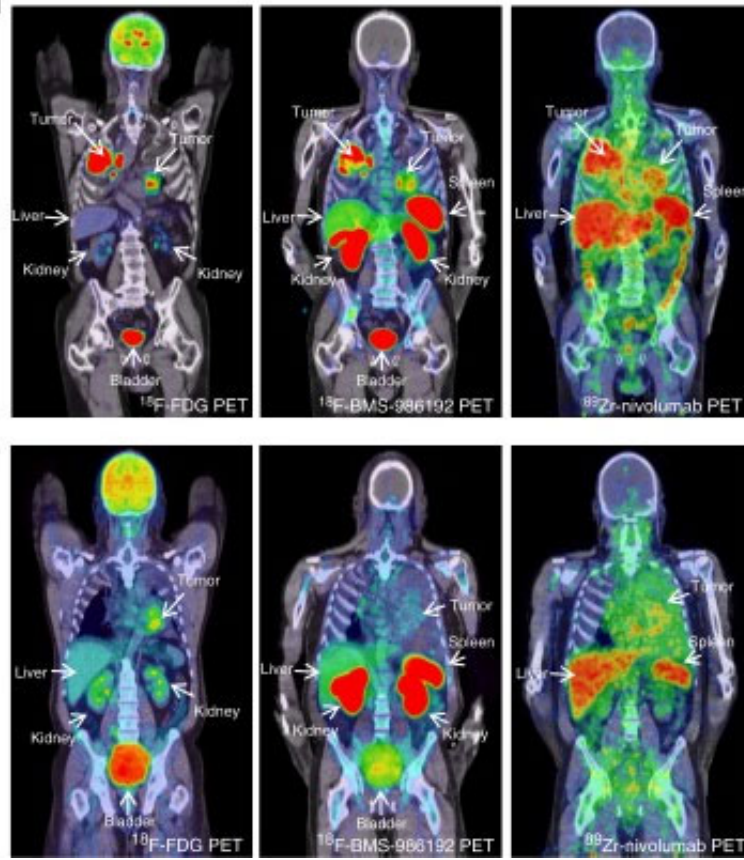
PET-images of two NSCLC patients. Upper row: patient with PD-L1 expression in 95% of the tumor cells. Lower row: Patient with tumor PD-L1 expression < 1%. ^{18}F -FDG PET (left panels) demonstrates high glucose metabolism of tumors in both lungs and mediastinal lymph nodes. ^{18}F -BMS-986192 PD-L1 PET (middle panels) and ^{89}Zr -labeled Nivolumab PD-1 PET (right panels) demonstrate high but heterogeneous tracer uptake in tumors of upper patient and low heterogeneous tracer uptake in the tumor of lower patient (31).
